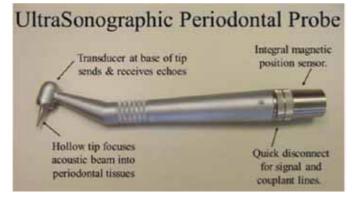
Ultrasonographic periodontal probe
